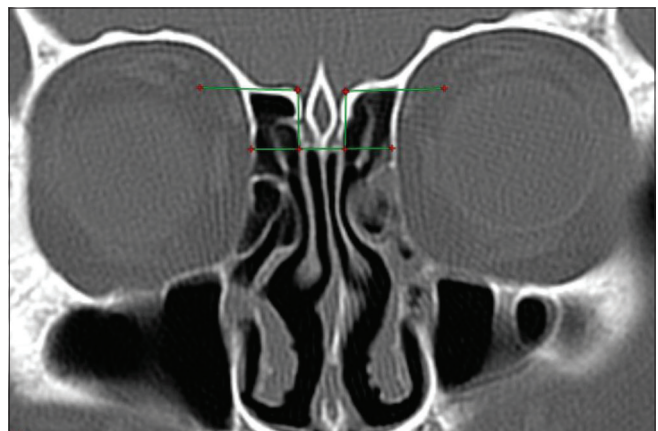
Coronal CT demonstrating type III Keros classification. Here the olfactory fossae are very deep compared with types I and II
